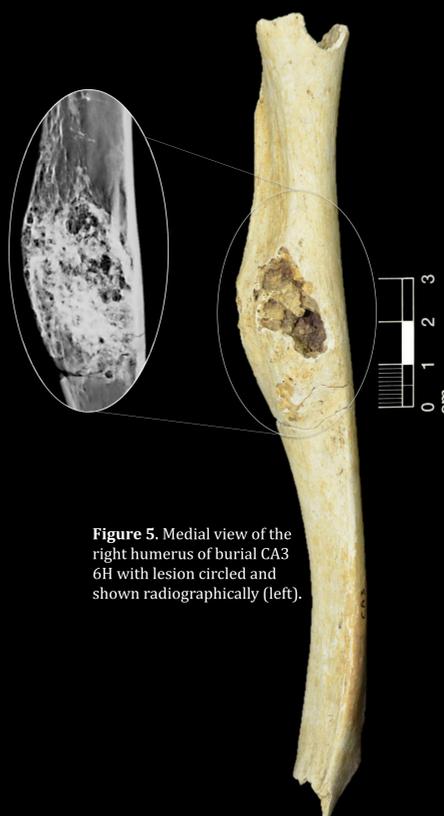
Medial view of the right humerus of burial CA3 6H with lesion circled and shown radiographically (left).
